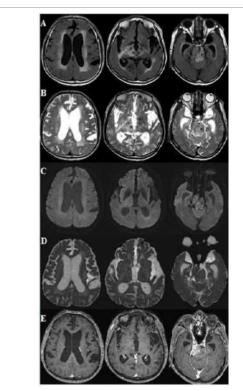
Axial magnetic resonance images of brainstem. Brain magnetic resonance imaging (MRI) 1 month after symptom onset, showing hyperintensity involving the periventricular area, midbrain, and pons on fluid-attenuated inversion recovery (FLAIR) images (A), and T2-weighted images (B). Diffusion-weighted image shows near isointensity (C) and the corresponding apparent diffusion coefficient (ADC) map shows slightly increased diffusion (D) in the brainstem. No evidence of abnormal enhancement was found in the brain parenchyma except in the right cerebellopontine angle (CPA) meningioma (E).
